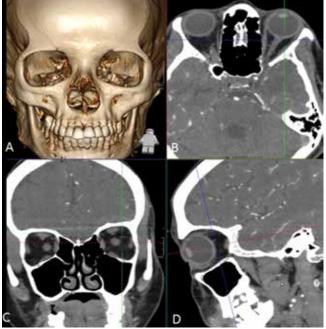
3D Volume Rendered (3D VR). (A) Reconstructions and Multiplanar Reconstructions (MPR) in any plane (B, C,D) created from thin axial sections of CT can be used to demonstrate pathology more clearly.
